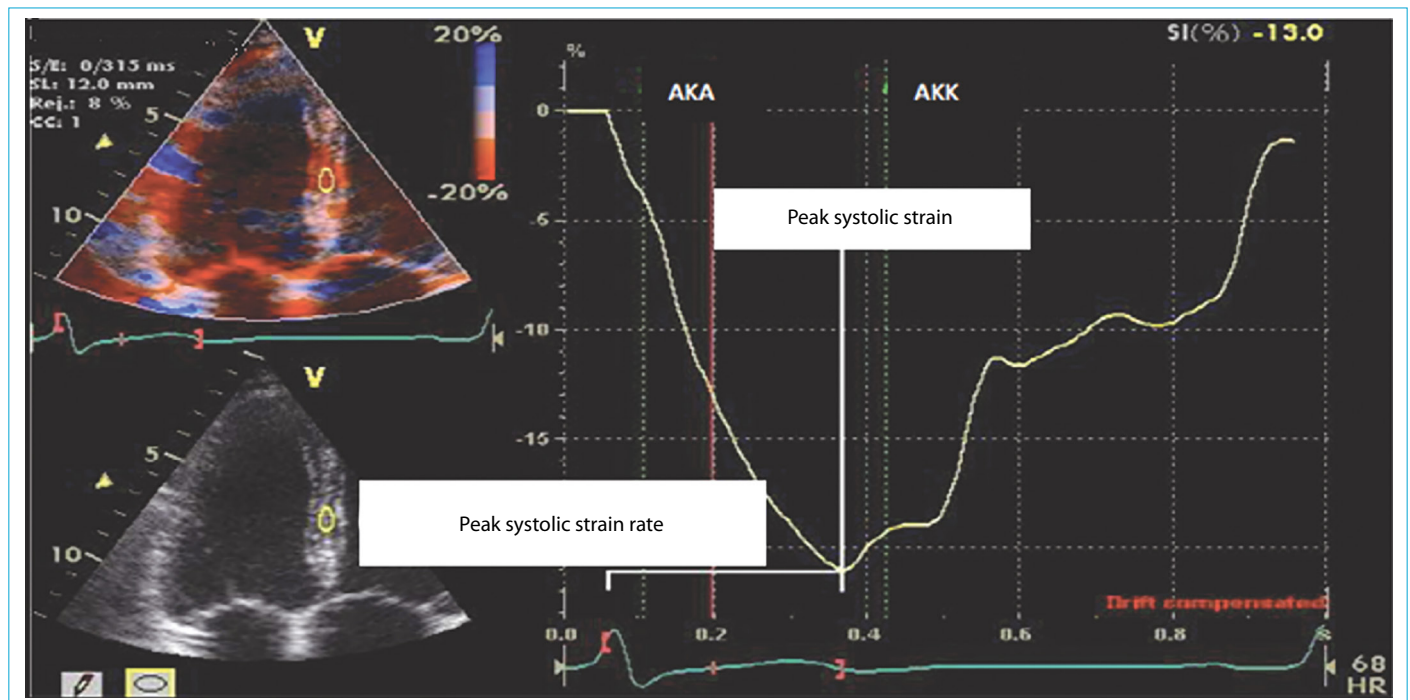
Longitudinal strain and strain rate measurement from an apical four-chamber image AKA: Aortic valve opening; AKK: Aortic valve closure.
